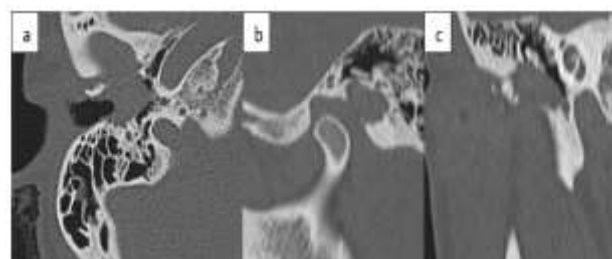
Temporal bone CT images showing EACC with multiple wall erosion and extension to TMJ, mastoid air cells, and FN canal, a) axial CT image shows erosion of the anterior and posterior walls of the EAC with involvement of the TMJ, mastoid air cells, and FN canal; b) sagittal CT image shows erosion of the anterior and posterior walls of the EAC with involvement of the TMJ, mastoid air cells, and FN canal; c) coronal CT image shows erosion of the EAC floor.
